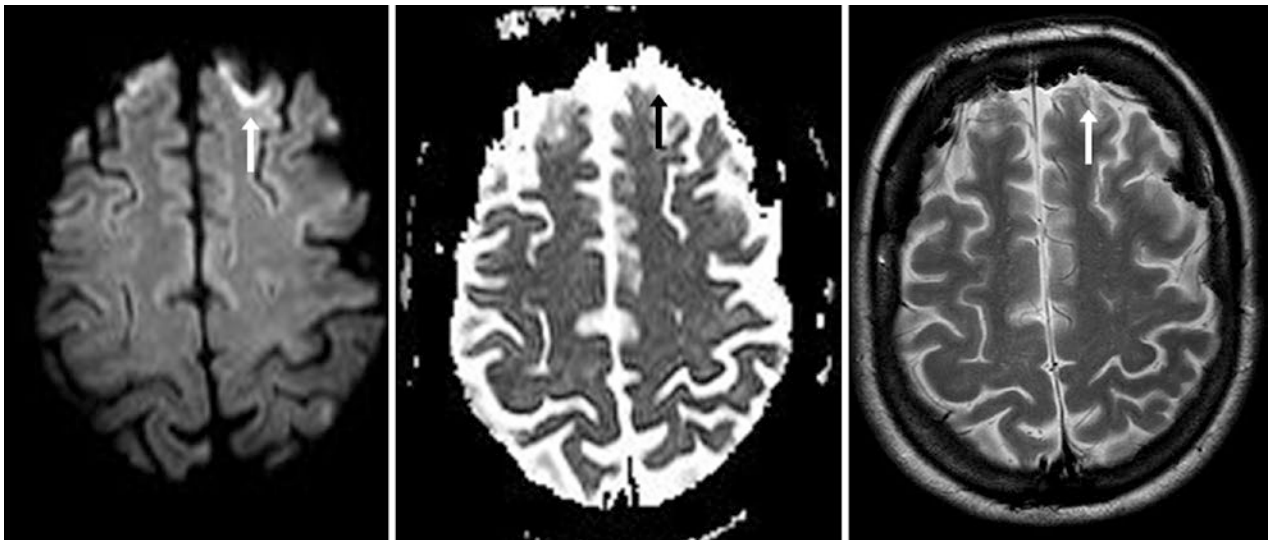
A 3 T DWI MRI (*left*) in a 53-year-old has focal bright susceptibility artifact (*arrows*), which is only minimally visible on an ADC map (*middle*). On T2WI (*right*), the air-bone interface artifact is
